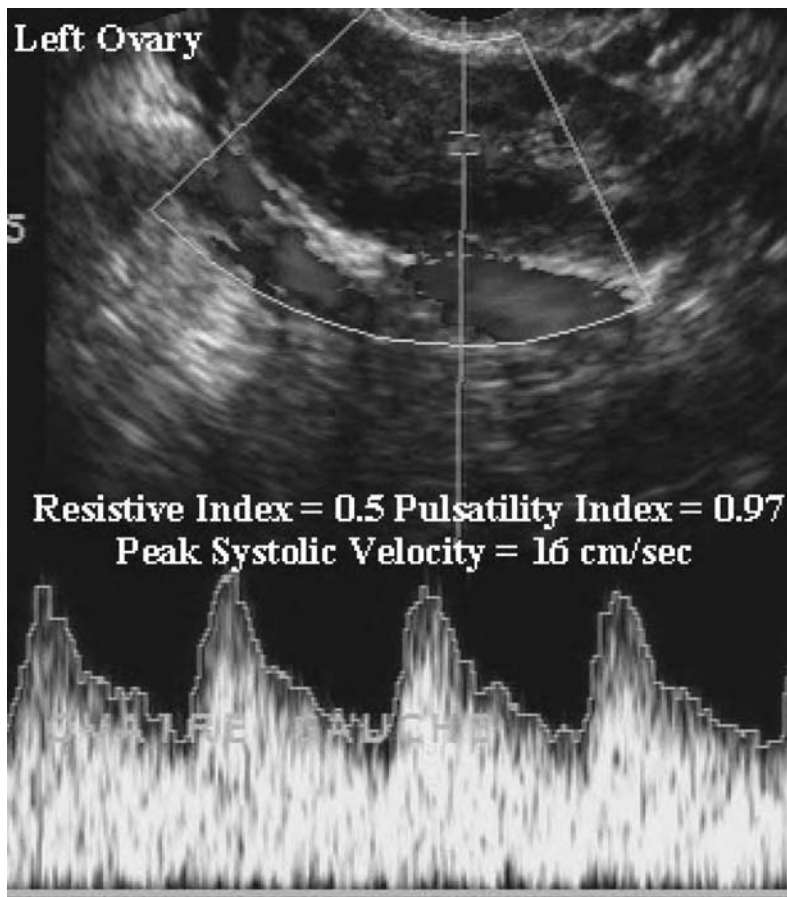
Polycystic ovary, as imaged by color and pulsed Doppler. The arterial flow is more easily depicted in PCOS than in the normal ovary, displaying low resistance indexes.
